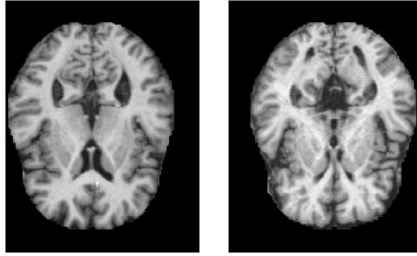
Examples of the OASIS MRI slices. CN on the left and AD on the right.
